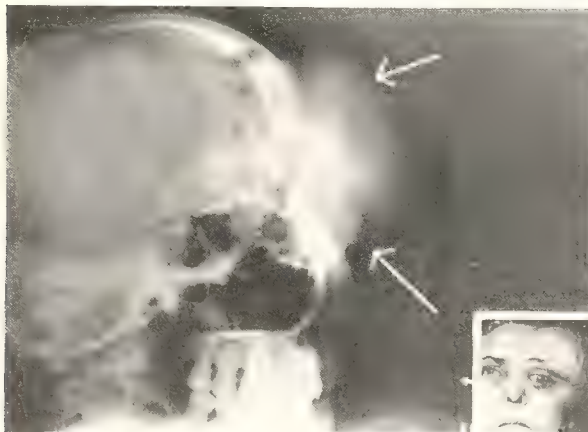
Carcinoma of the skull, possibly metastatic. The roentgenogram shows extensive bone destruction as well as a soft tissue mass.
